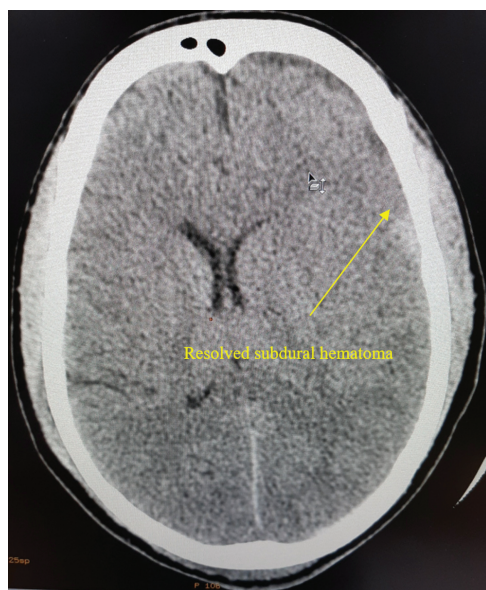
Noncontrast computed tomography head after 1 week of admission.
